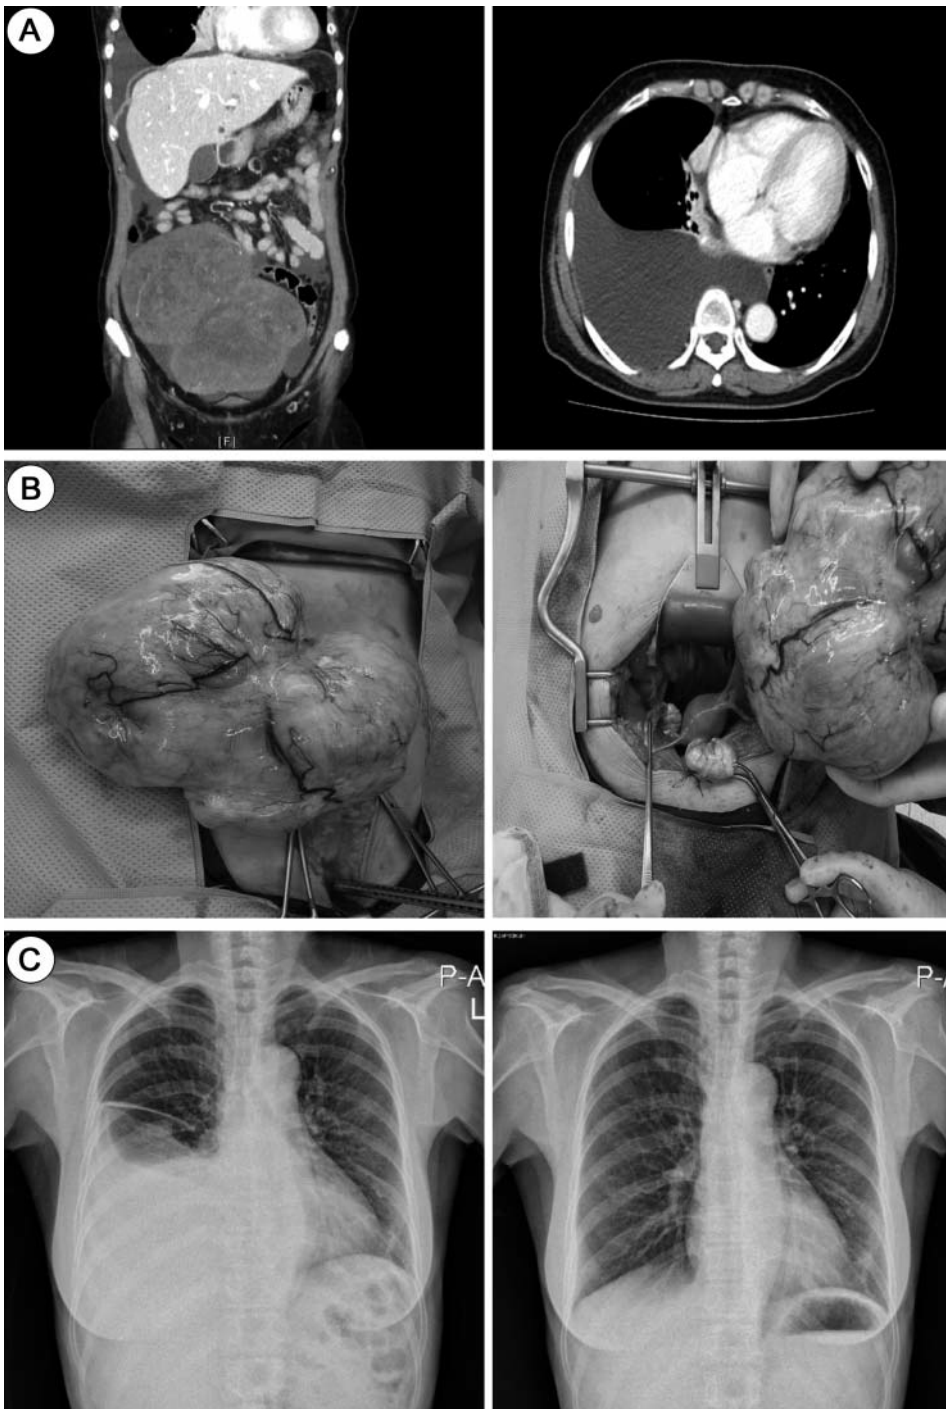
(A) Computed tomography reveals a 18.5 x 17.5 x 17.3 cm sized solid mass with a moderate amount of ascites and a right pleural effusion. (B) Intraoperative gross appearance of the left ovarian tumor. (C) Comparison of the chest X-ray of before (left) and after removal of the tumor (right). Complete remission of the pleural effusion was observed on the fifth post-operative day.
